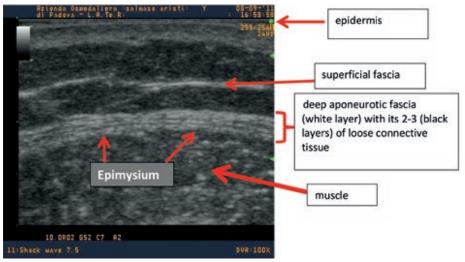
Ultrasound of normal Fascia lata. Note the minimal thickness of the loose connective tissue layers. (Reproduced with permission of Antonio Stecco, MD)
